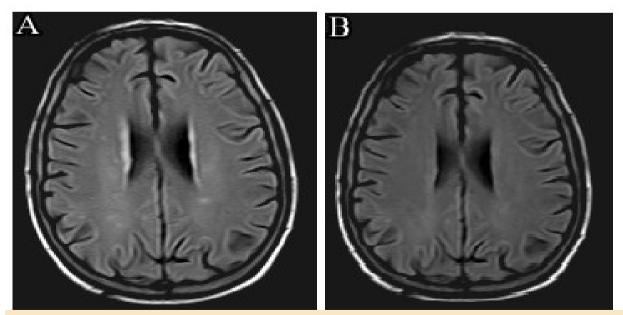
Axial T2-weighted fast FLAIR images (A) pre-transplantation showing peri-ventricular sheets and some foci of WMLs. (B) post- transplantation showing complete disappearance of the WMLs.
